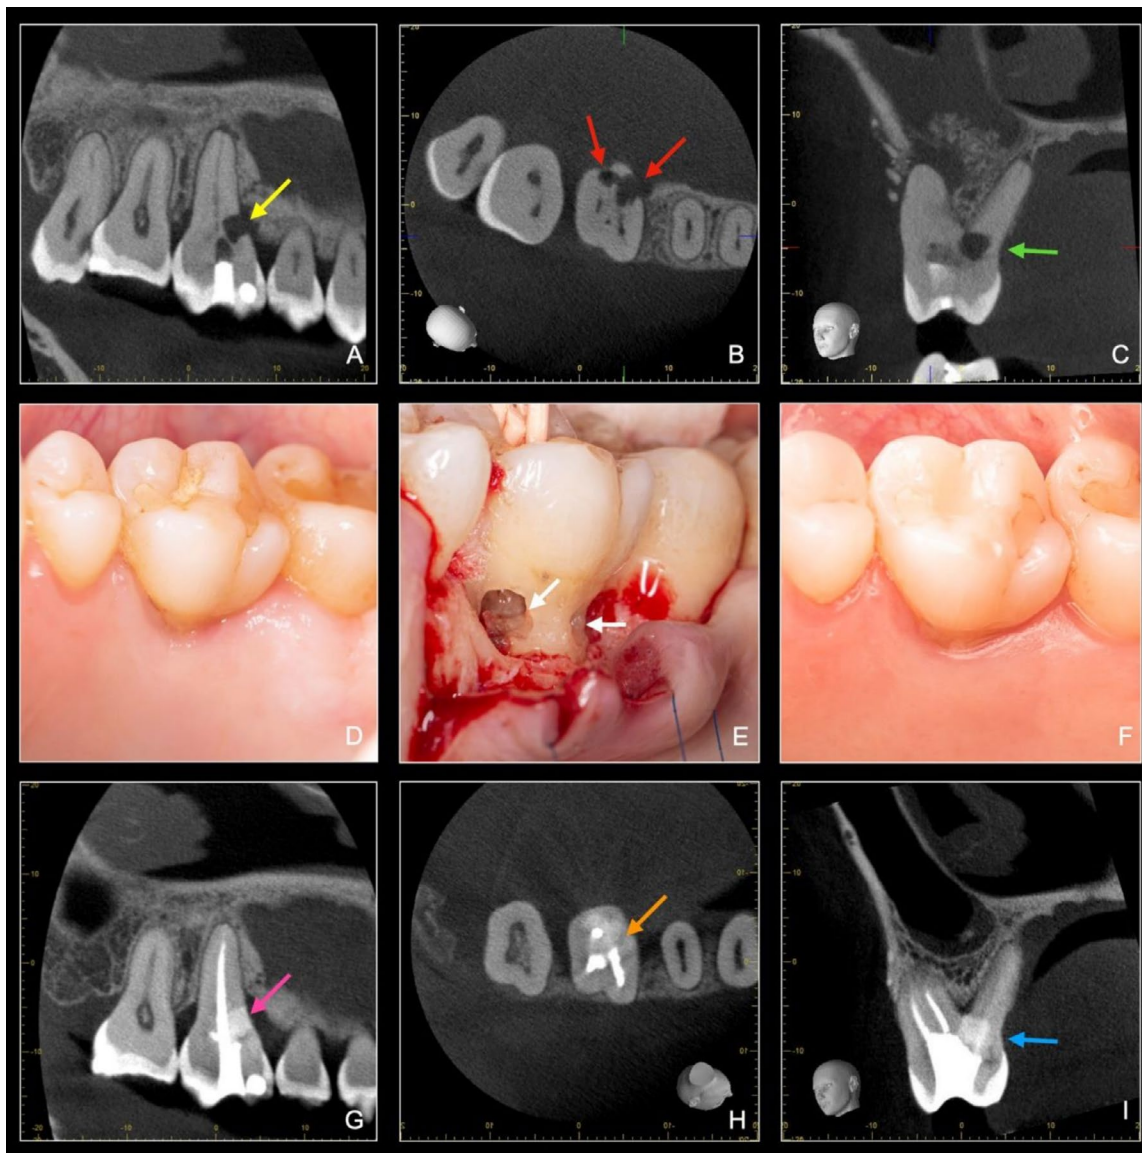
Treatment option 2. External repair & endodontic treatment. (A–D). Previously initiated endodontic treatment and external cervical resorption (ECR) involving the palatal root. (A) Sagittal view (yellow arrow), (B) axial view (red and orange arrows), and (C) coronal view (green arrow) from CBCT confirmed the presence of ECR. (D) Clinical examination revealed no supragingival cavitation. (E) Surgical management included flap elevation to expose the resorptive defects (white arrows). After removal of all fibroconnective tissue, the canals were protected with gutta-percha cones to prevent obliteration during sealing of the cavities with Biodentine (Septodont, France). Endodontic treatment was then completed. (F) 2 years later, the patient presented with normal clinical appearance and (G) sagittal view (pink arrow) (H) axial view (orange arrow) and (I) coronal view (blue arrow) from CBCT revealed stable sealing of the ECR.
